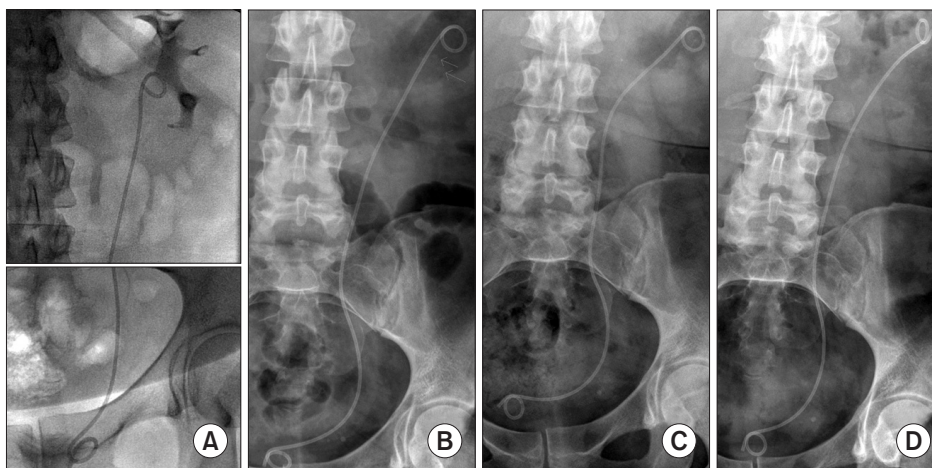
Study patient treated by shock wave lithotripsy (SWL) secondary to stenting with pushback. X-rays performed before and after treatment show high variability of distal stent location. (A) Intraoperative x-ray. (B) One day after stent insertion. (C) Three weeks after insertion (before SWL). (D) Three weeks after SWL (before stent removal).
